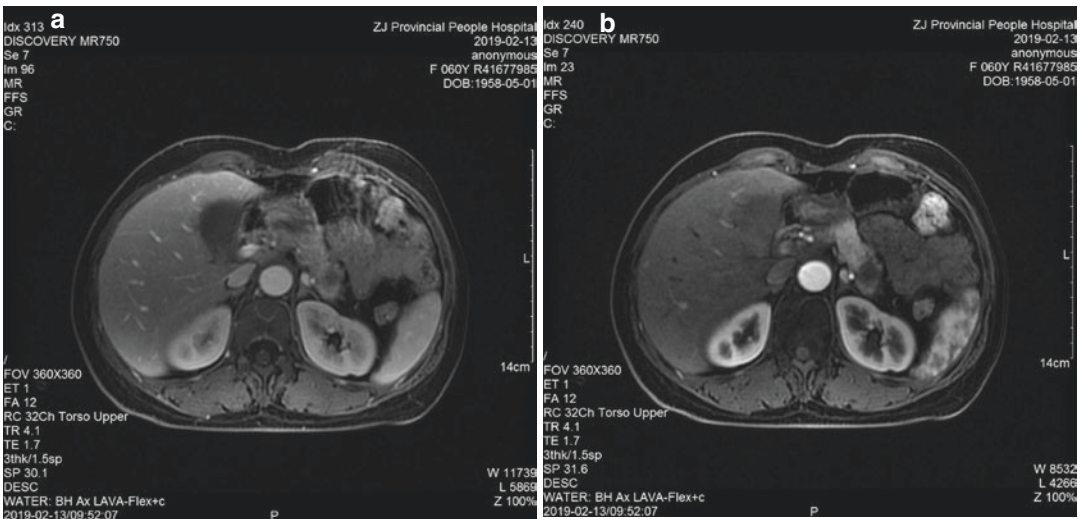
(a, b) MRI showed a mass in the body of the pancreas
